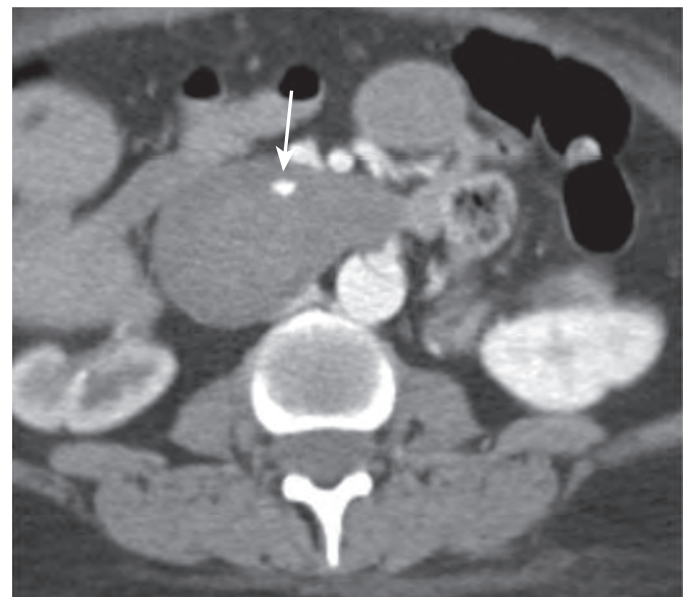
Acute gastrointestinal bleeding on CT. Contrast-enhanced arterial phase CT image demonstrates active extravasation within the duodenum (arrow), which is distended with hematoma. This was found to represent a bleeding duodenal ulcer when further evaluated with endoscopy.
